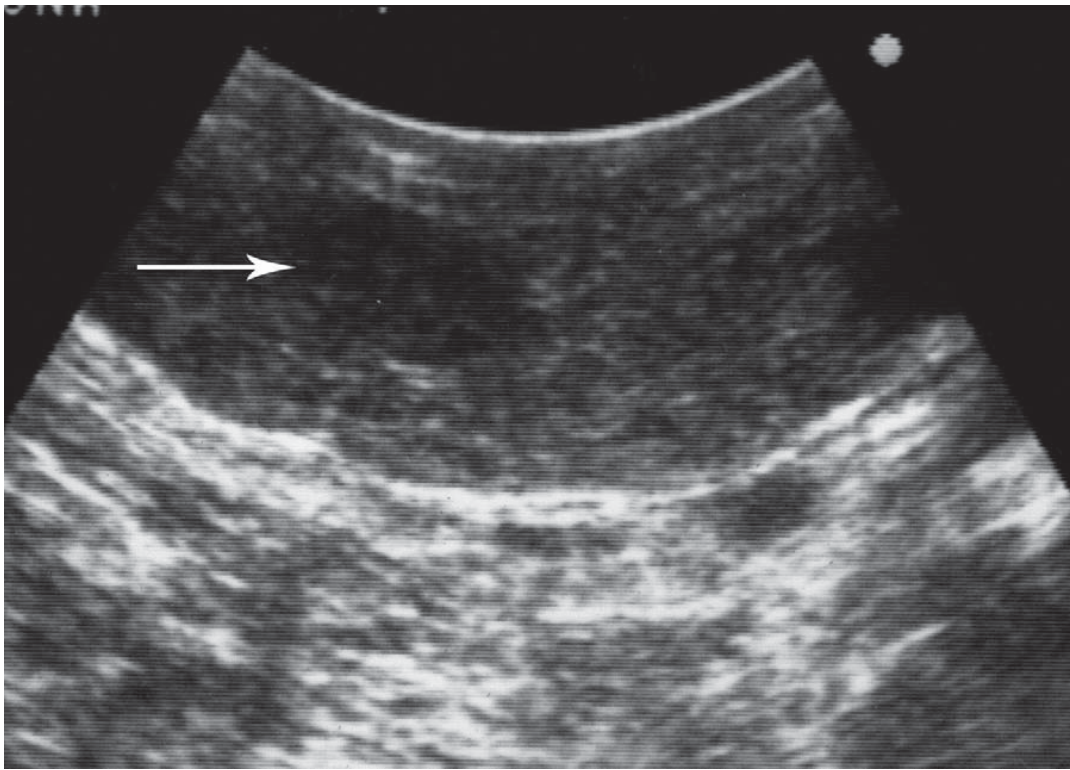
Intraoperative ultrasonography with a high resolution probe shows a small 1 cm insulinoma (arrow) not identified with preoperative MRI or CT. (Color version of figure is available online.)
